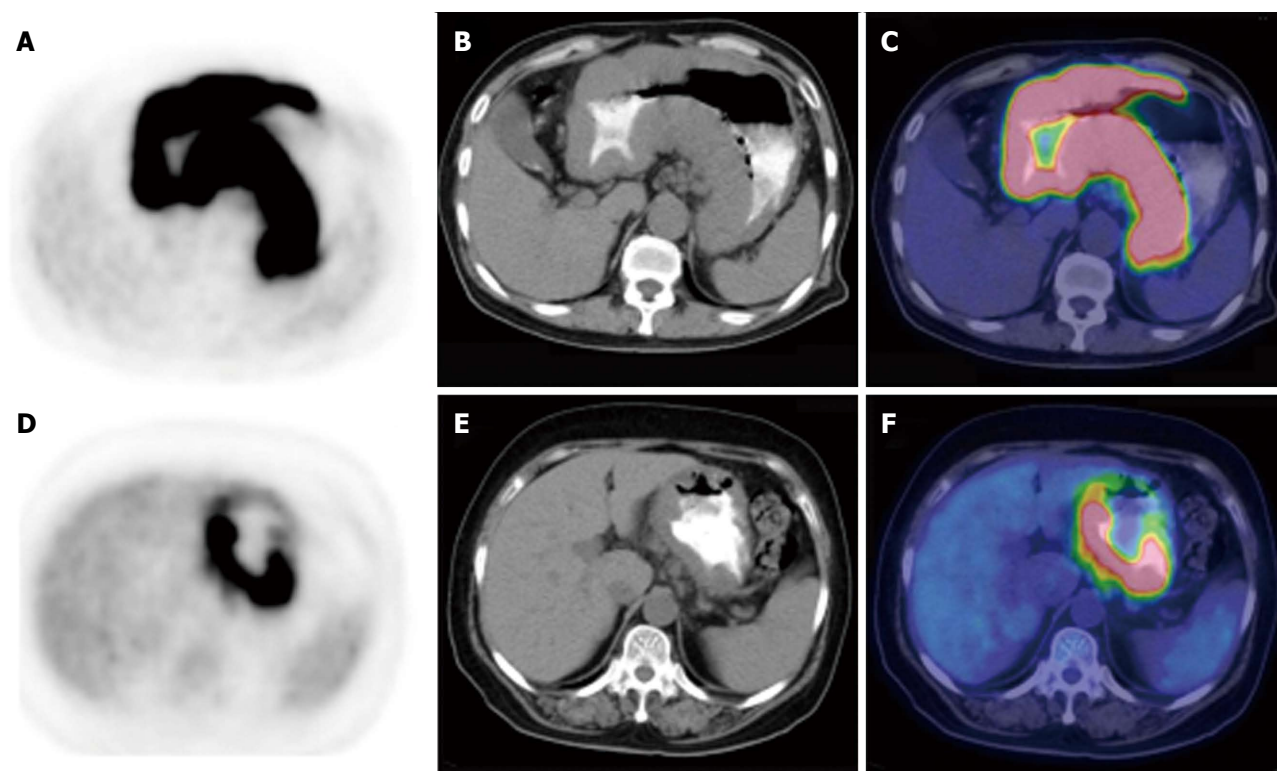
Comparison of gastric lymphoma and gastric carcinoma with diffuse fluorodeoxyglucose uptake. A-C: PET (left column), CT (middle column) and PET/CT fused images (right column) of a 74-year-old man with DLBCL (SUVmax 24.5, THKmax 4.3 cm); D-F: A 64-year-old woman with poorly differentiated gastric adenocarcinoma (SUVmax 28.2, THKmax 2.4 cm). CT: Computed tomography; PET: Positron emission tomography; SUVmax: Maximal standard uptake value; THKmax: Maximal thickness.
